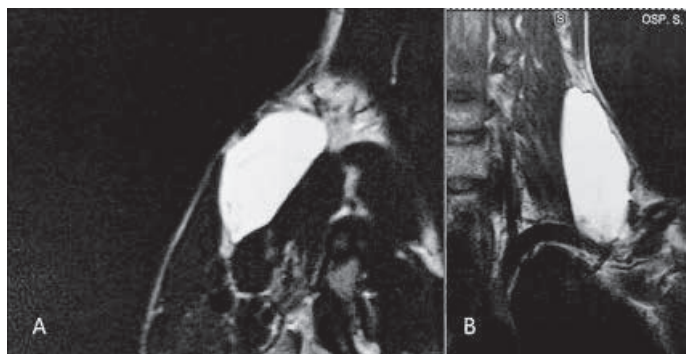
MR images of a lymphangioma of the left supraclavicular region with extension to the laterocervical area and developing in between the muscles (A: latero-lateral scan; B: antero-posterior scan)
